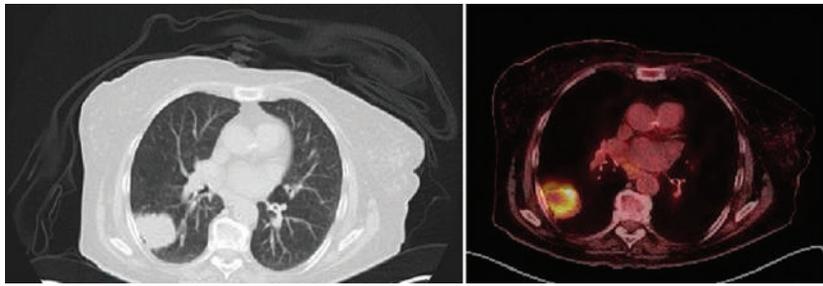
Positron emission tomography image of right lower lobe 4.7cm lung mass. Standardized uptake value (SUV) of 10. Corresponding computed tomography chest imaging of right lower lobe 4.7-cm lung mass. (Courtesy Cleveland Clinic, Cleveland, OH.)
